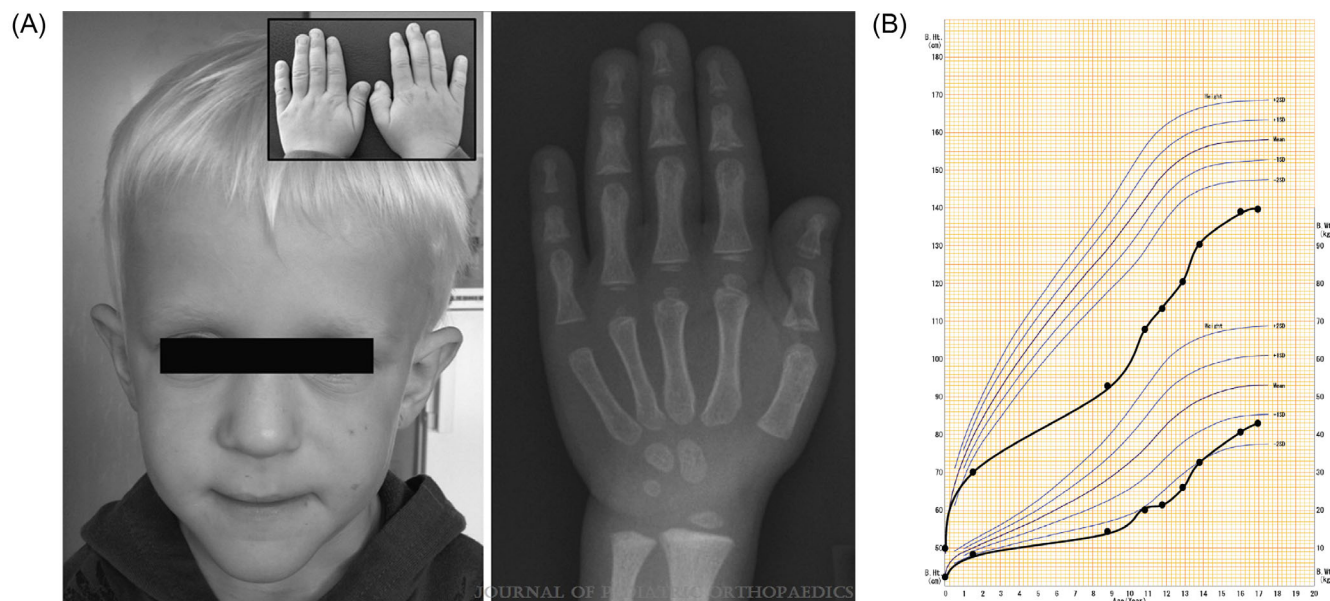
Appearance and growth curves of Trichorhinophalangeal syndrome patients. (A) Fine scalp hair, pear-shaped nose, long philtrum, and protruding ears are observed. The inset image shows the shortening of the digit length of the same patient. The right radiographic image of the left hand shows cone-shaped epiphyses of the middle phalanges of the second to fifth fingers. Adapted from “Trichorhinophalangeal Syndrome Type I: A Novel mutation and Perthes-like Changes of the Hip in a Family With 4 Cases Over 3 Generations” by Hufeland, Rahner, Krauspe from the *Journal of Pediatric Orthopedics*. By permission of Wolters Kluwer Health, Inc. (B) Growth curve of patient with Trichorhinophalangeal syndrome shows severe growth failure during childhood. Adapted from “A novel frameshift mutation in the TRPS1 gene caused Tricho-rhino-phalangeal syndrome type I and III in a Japanese family” by Itoh, Kittaka, Niida, Saikawa from *Clinical Pediatric Endocrinology*. By permission of Clinical Pediatric Endocrinology.
